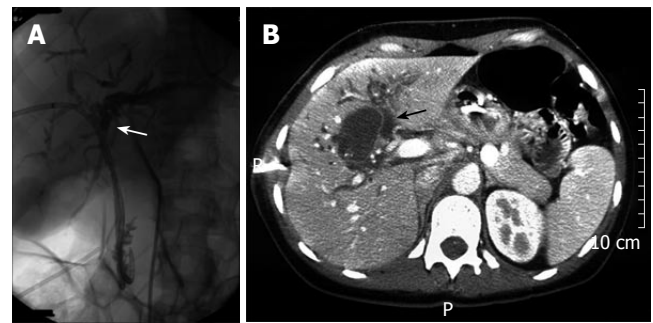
Percutaneous transhepatic drainage (PTD) showing complete obstruction at level of the proximal bile duct (A), abdominal CT showing a cystic lesion with irregularly thickened wall in conjunction with dilated intrahepatic bile ducts (arrow) (B) in case 5.
